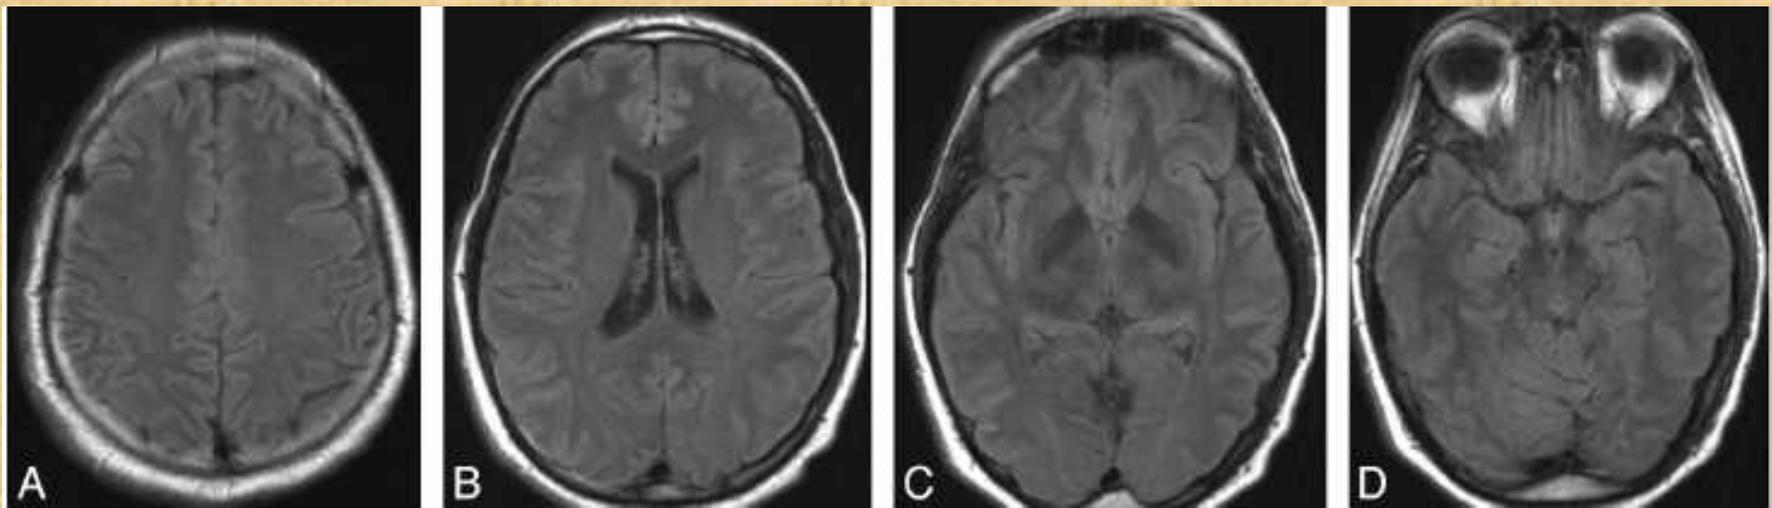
Follow-up FLAIR images after a gluten-free diet show complete resolution of signal-intensity abnormalities.
